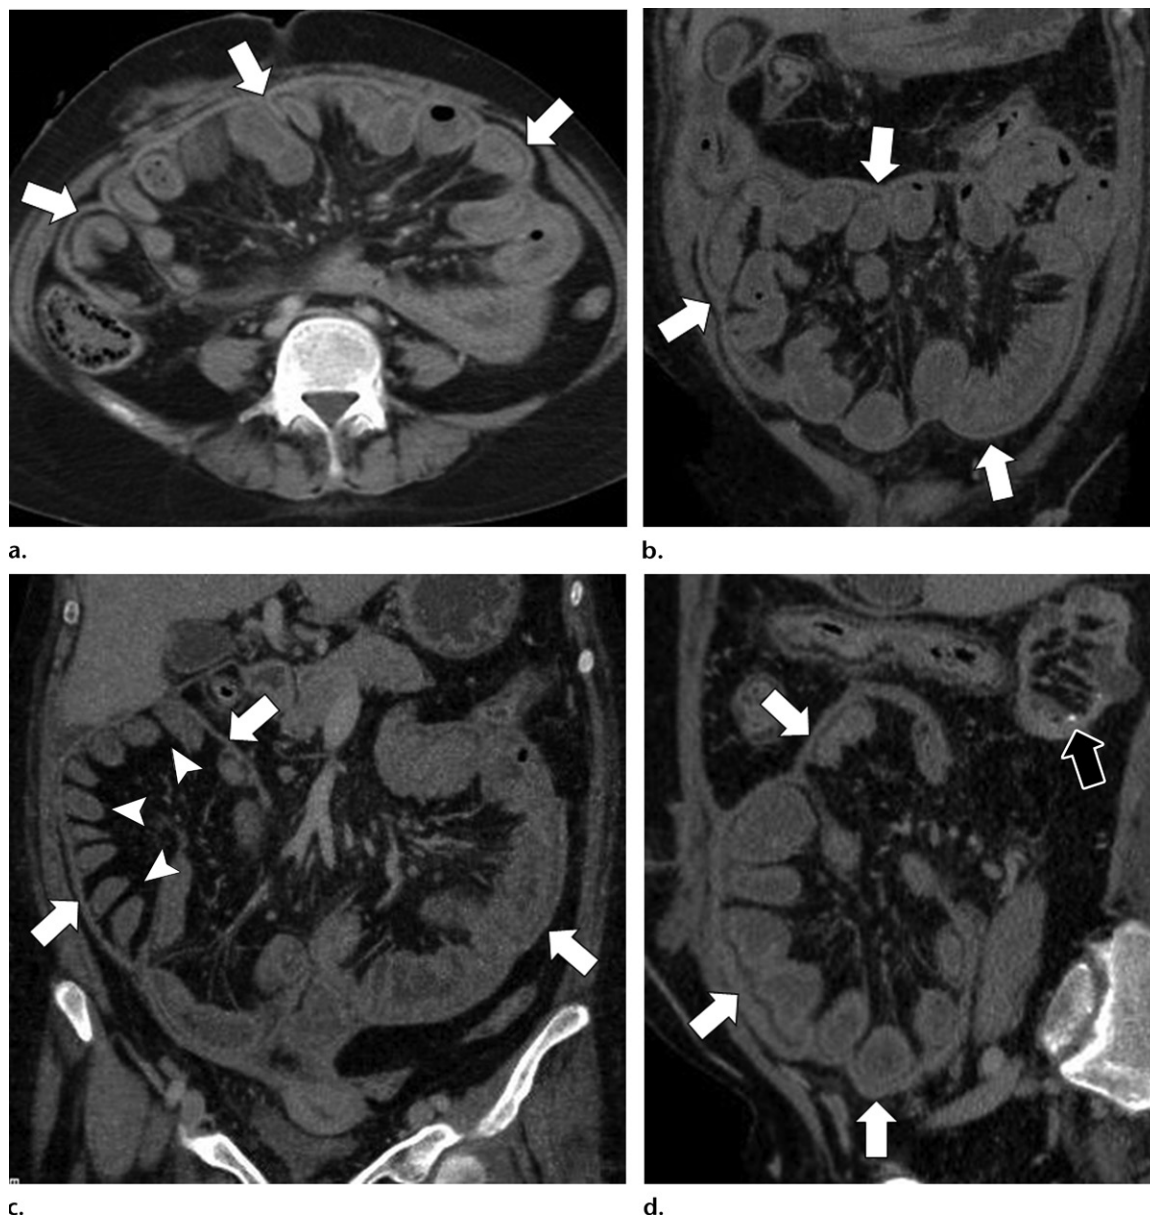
EPS in a 43-year-old woman undergoing therapy with continuous ambulatory peritoneal dialysis. (a) Axial contrast material-enhanced CT image shows a thick soft-tissue mantle of EPS encasing the bowel loops (arrows). (A full DICOM image stack is available online.) (b, c) Coronal contrast-enhanced CT images (b obtained more anteriorly than c) show a thick soft-tissue mantle of EPS encasing the bowel loops (arrows) and the characteristic pattern of arrangement of the small-bowel loops (arrowheads on c). (d) Sagittal contrast-enhanced CT image again shows a thick soft-tissue mantle of EPS encasing the bowel loops (white arrows). Note also the atrophic kidney (black arrow) in this patient with end-stage renal disease.
